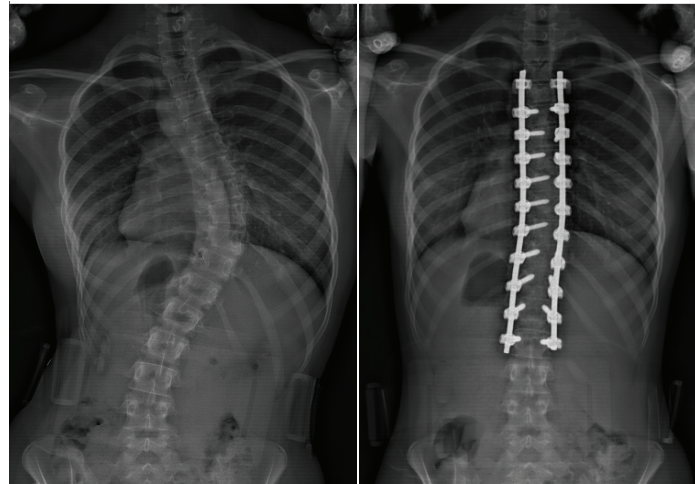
Before (left) and after (right) radiograph examples of spinal instrumentation
